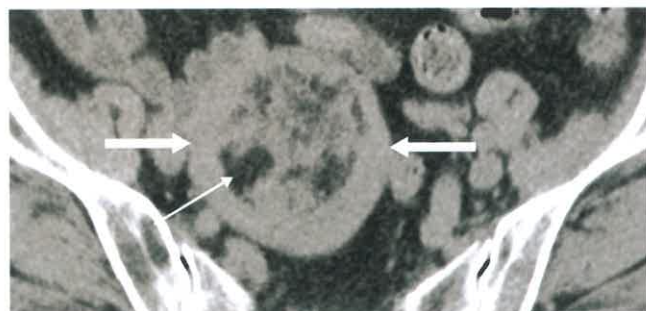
Lipoleiomyoma. Axial CT performed without contrast demonstrates a fat-containing myometrial tumor in the uterus (between *fat arrows*). Distinct fat attenuation (*skinny arrow*), equal to that of nearby pelvic fat, confirms the diagnosis of lipoleiomyoma.
